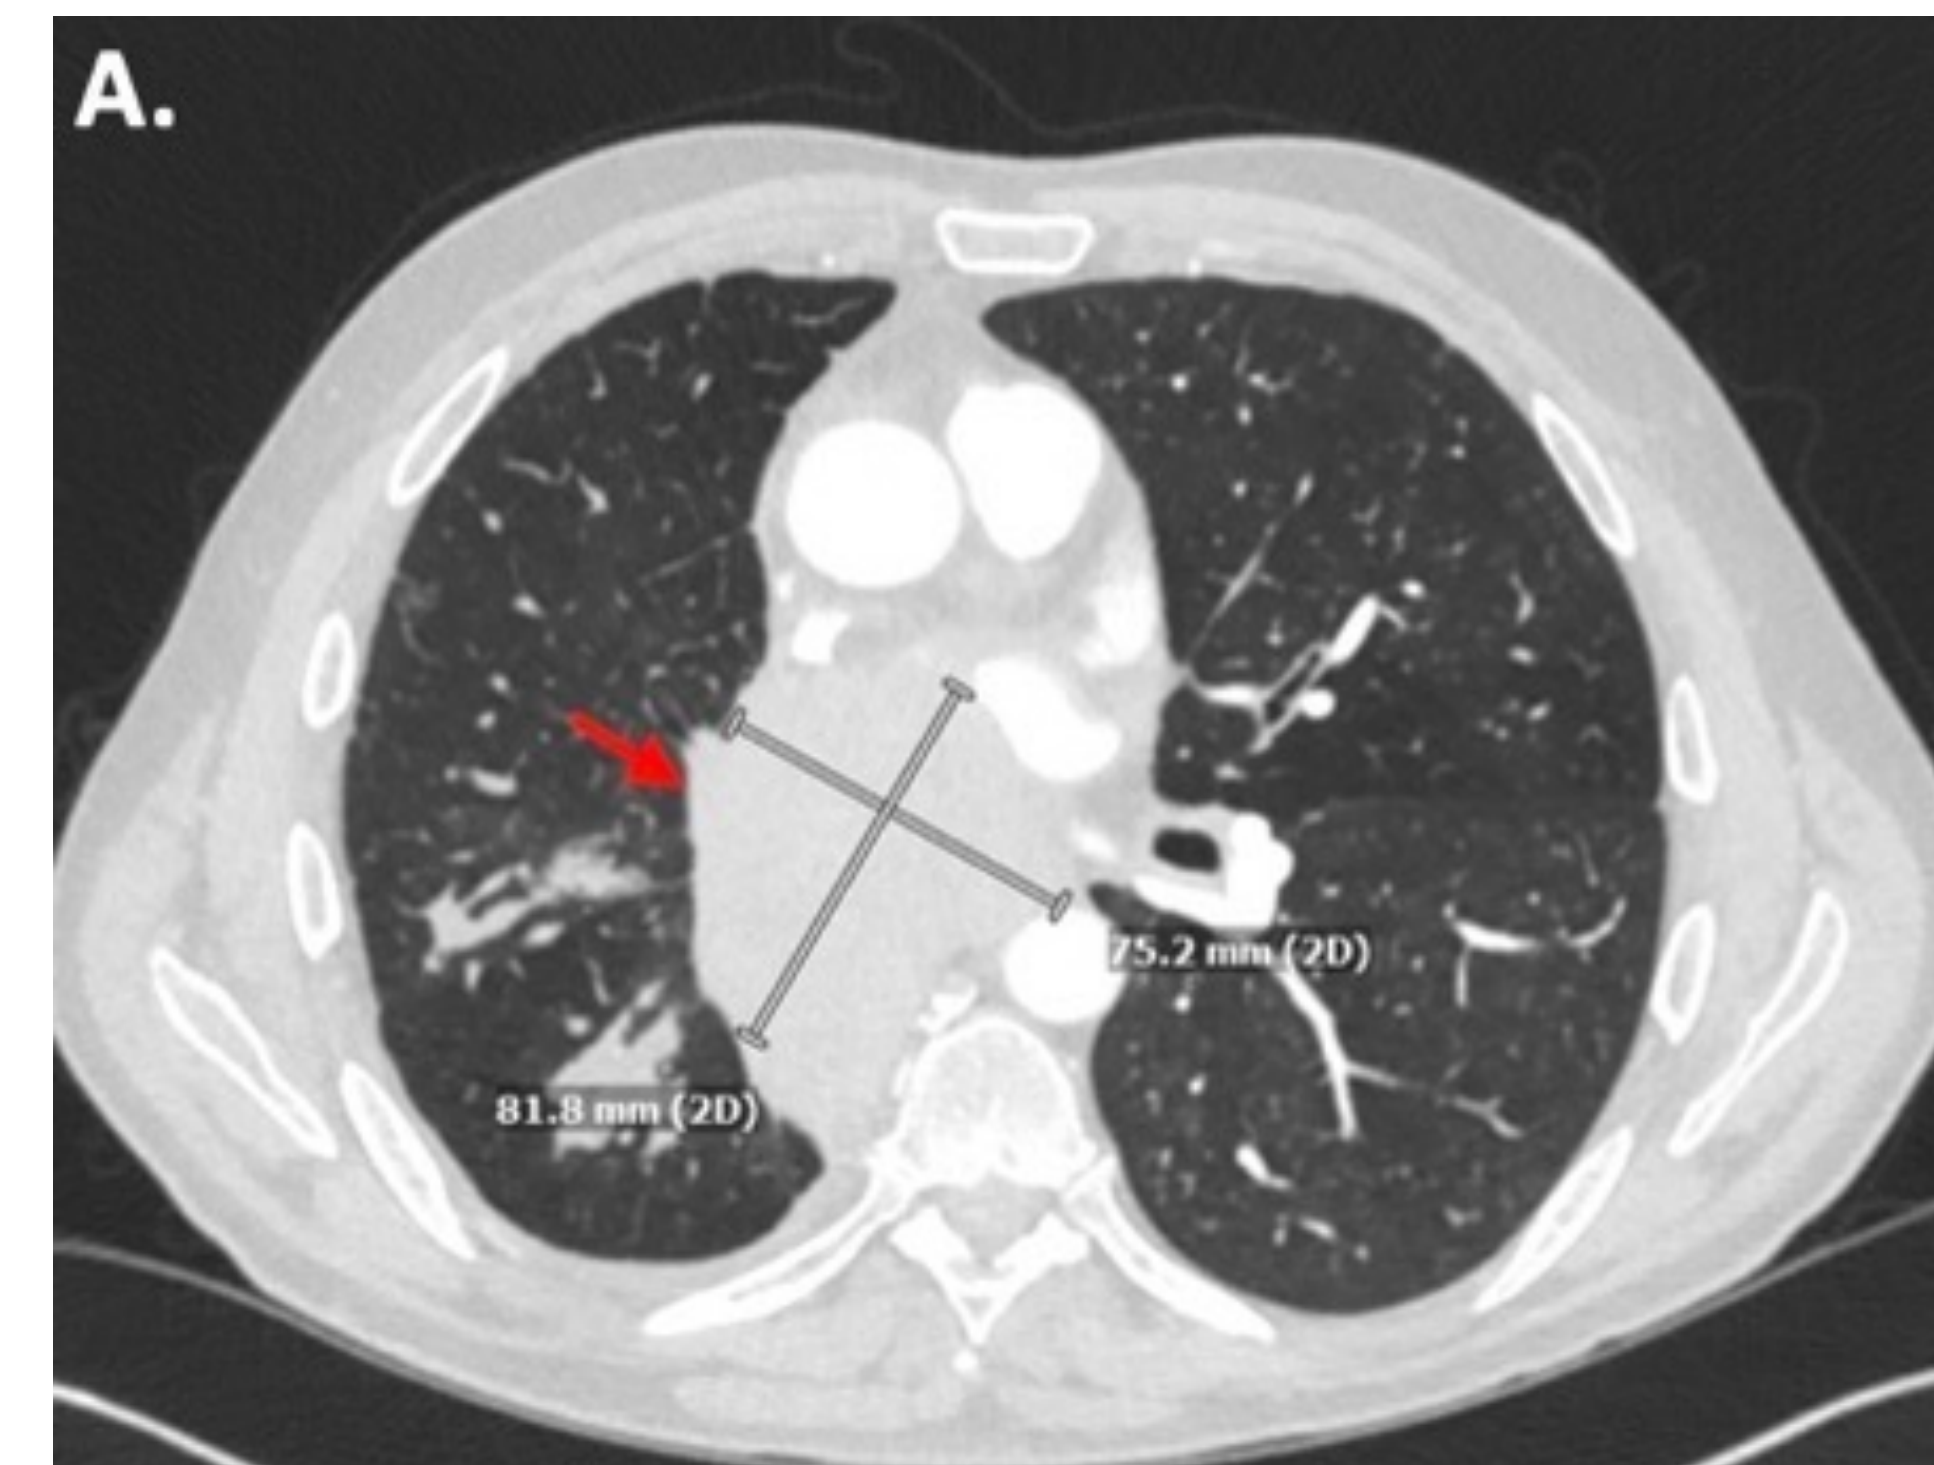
Initial CT Chest with findings of a right 8.0 x 7.5 cm mediastinal mass
